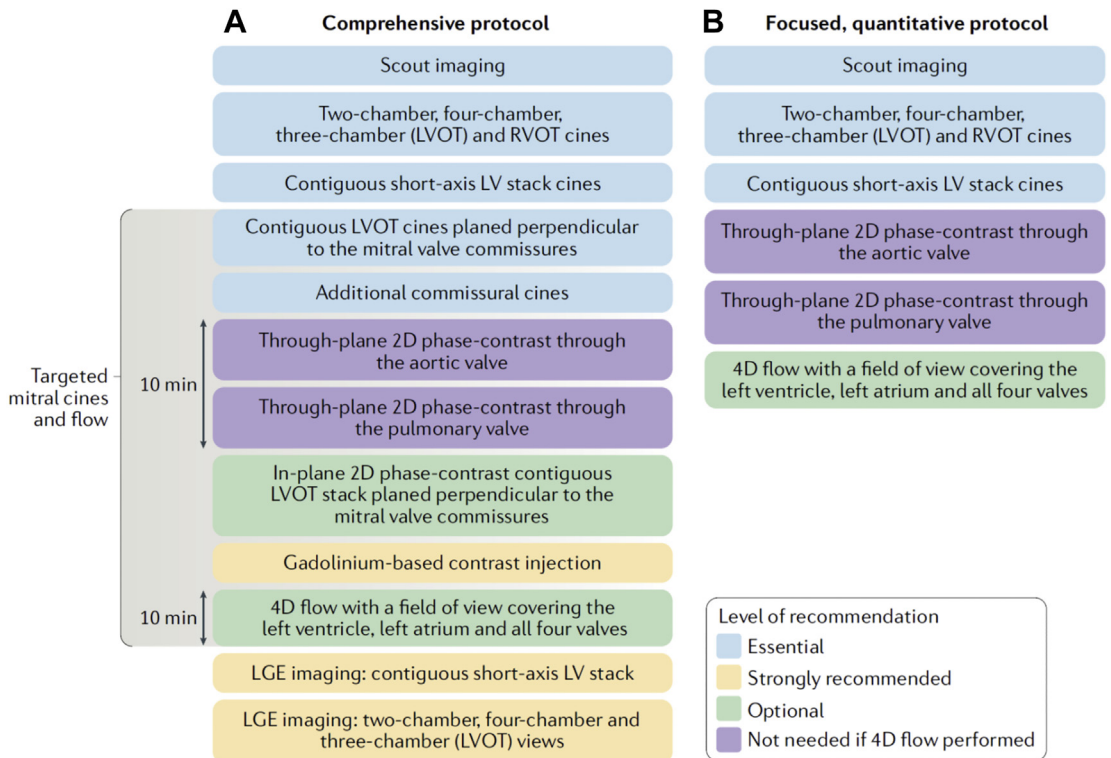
Recommended cardiovascular MRI protocols for the assessment of MR. Comprehensive cardiovascular MRI protocol for the assessment of MR (A). Focused, quantitative protocol (B). LGE, late gadolinium enhancement; RVOT, right ventricular outflow tract. (From Garg P, Swift AJ, Zhong L, et al. Assessment of mitral valve regurgitation by cardiovascular magnetic resonance imaging. *Nat Rev Cardiol.* 2020;17(5):298-312; with permission.)
